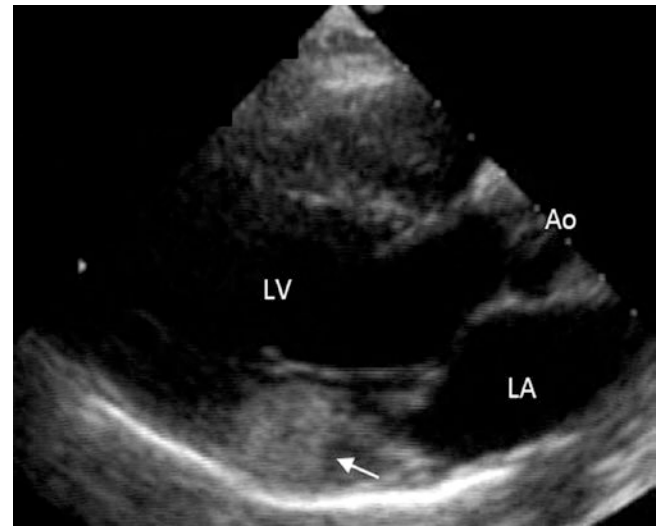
Parasternal long axis POC imaging. There is a solitary, well circumscribed, relatively immobile mass (arrow) situated at the basal posterior wall of the heart which is incidentally discovered by echocardiography. The echocardiographic feature is suggestive of ventricular fibroma. The *LV* left ventricle, *LA* left atrium, *Ao* aorta
